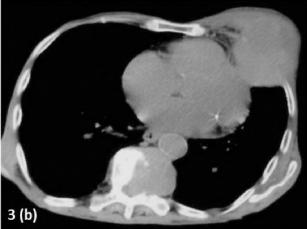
Axial CT scan of the chest showing mass in left anterolateral chest wall with intra & extrathoracic component along with destruction of adjacent rib and vertebral destruction with soft tissue component.
